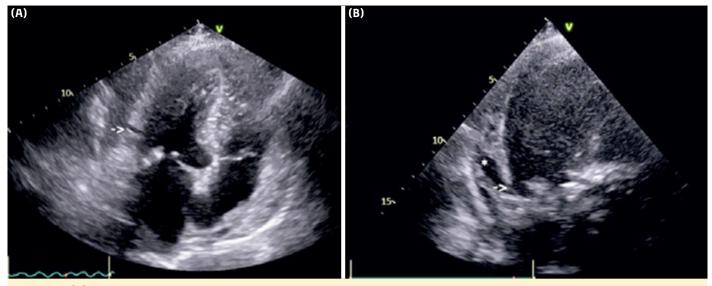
(A) Transthoracic echocardiography, apical four-chamber view, showing a left ventricular pseudoaneurysm in the inferolateral segment with a narrow neck (arrow indicates the neck of the pseudoaneurysm) (B) Modified image showing the left ventricular pseudoaneurysm (* indicates the pseudoaneurysm).
